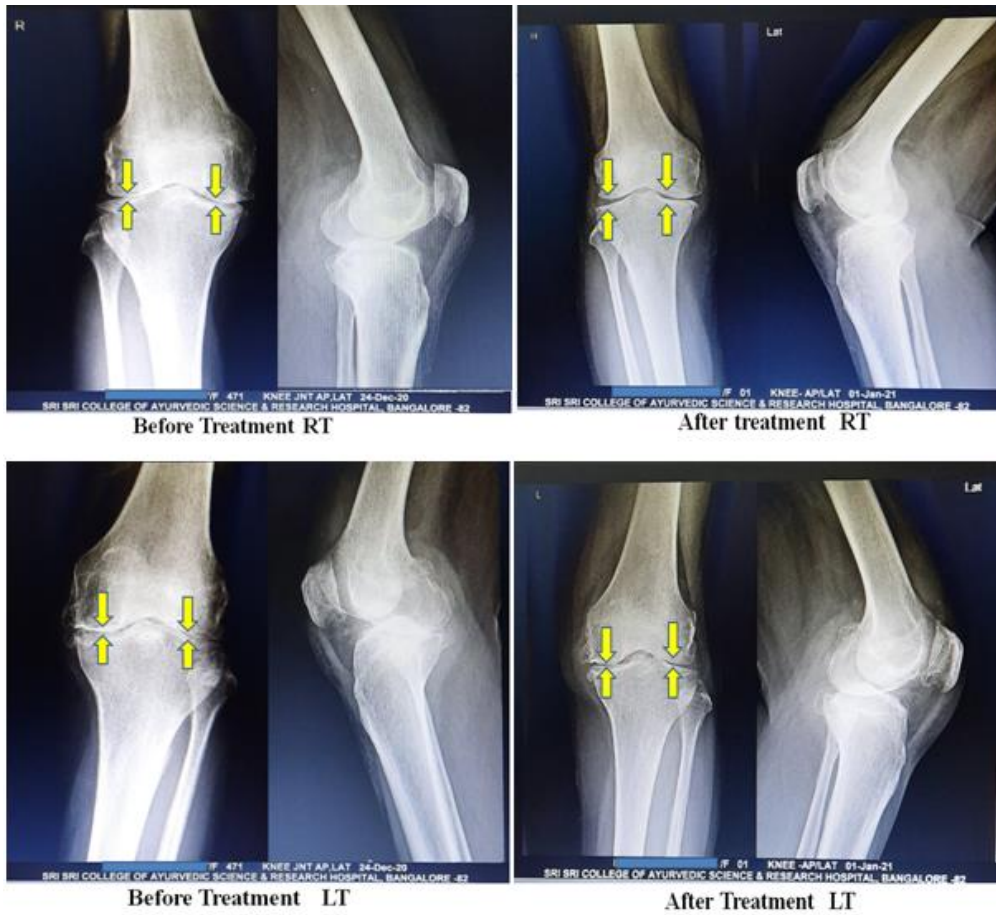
X-rays taken before and after treatment
